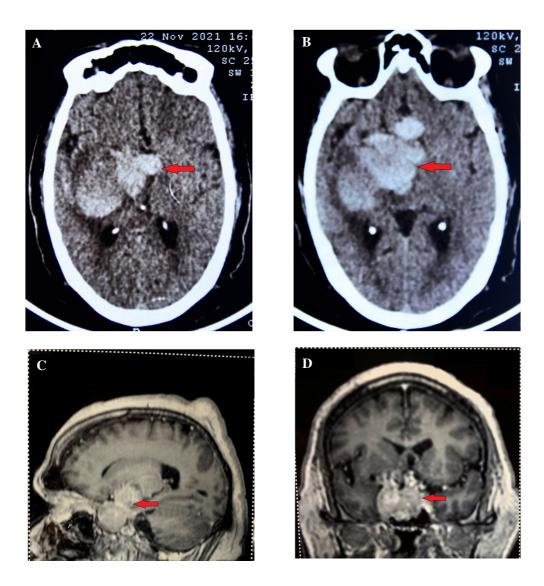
A & B: T1W magnetic resonance imaging of brain sagittal and coronal section showing lobulated sellar-suprasellar mass (35 mm× 60 mm × 55 mm) suggestive of pituitary macroadenoma (arrows). C & D: Non-contrast computed tomography head showing iso to hypodense mass (28 mm× 41 mm× 42 mm) mass suggestive of pituitary macroadenoma with intratumoral hemorrhage and right temporal and capsulo-ganglionic (36 mm× 38 mm) hemorrhage (arrows).
